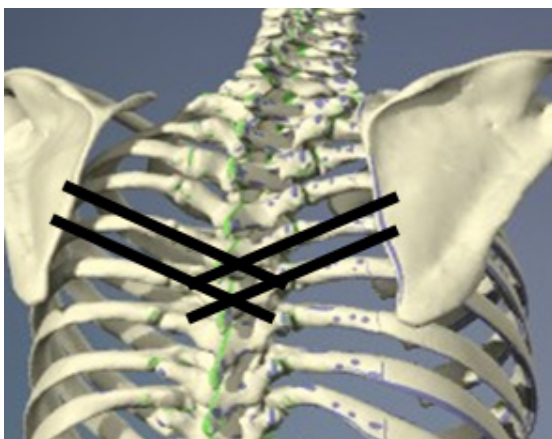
/ A. Preoperative x-ray B. Preoperative CT scan
